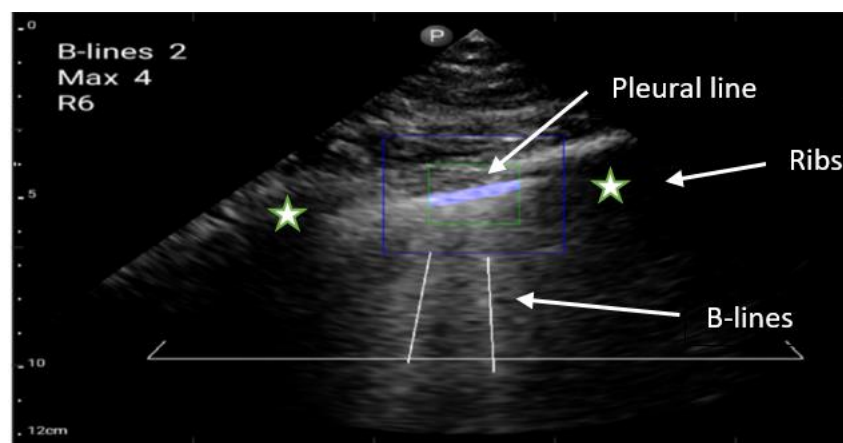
B-lines extending from pleural line to the bottom of the image. Ultrasonography image is made using a phased array Lumify transducer. Interstitial pulmonary edema accumulates with the number of B-lines. The pleural line is partly colored blue. Ribs are depicted as white stars and are recognizable by the black shadow underneath.
